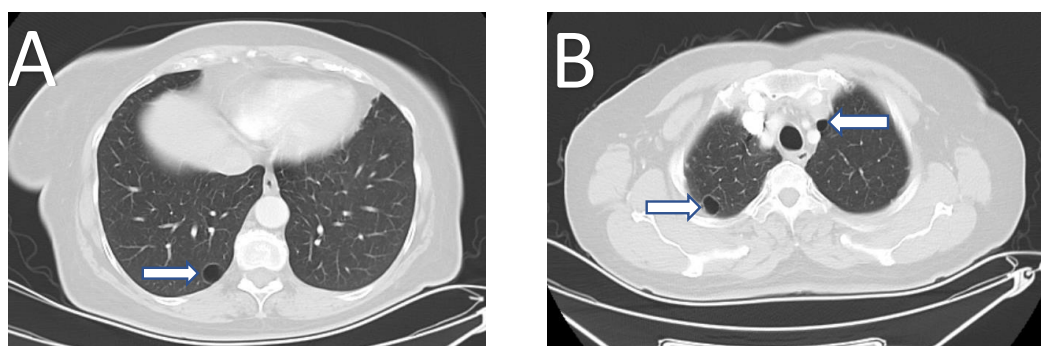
(A) Right pulmoner lower lobe posterolateral segmental 15mm nodule shown on torax CT (white arrow). (B) Right pulmoner upper lobe posteroapical segmental 15mm nodule and left pulmoner lobe paratracheal 5mm nodule shown on thorax CT (white arrow).
